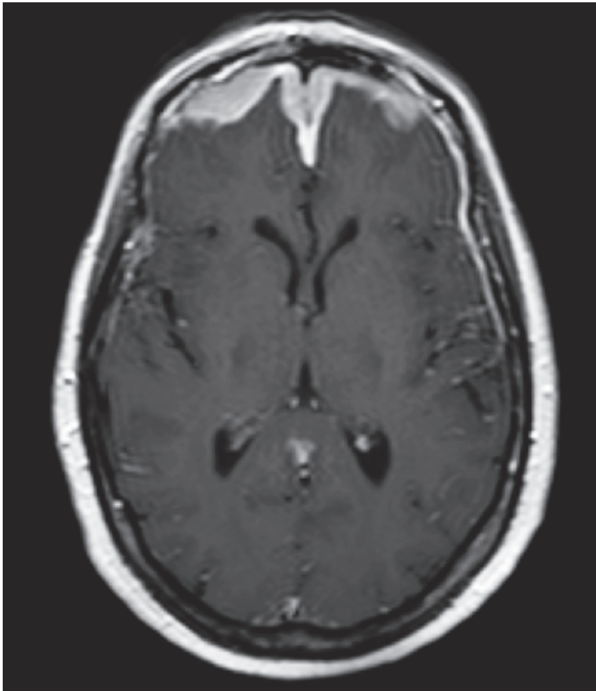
T₁-weighted post contrast magnetic resonance imaging (MRI) at initial diagnosis showing dural thickening and enhancement along the bilateral frontal lobes.
